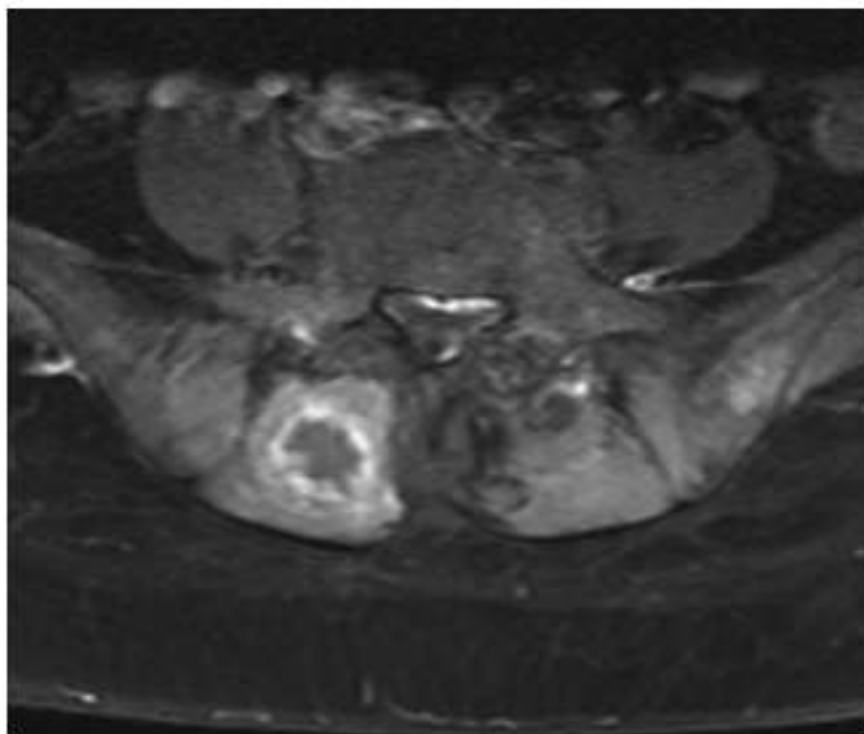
MRI in axial plane showing a mass of a maximum size of 3.5 cm in diameter in the right paravertebral muscles with central necrosis and an enhanced hyperintense rim after contrast medium injection. MRI: magnetic resonance imaging.
